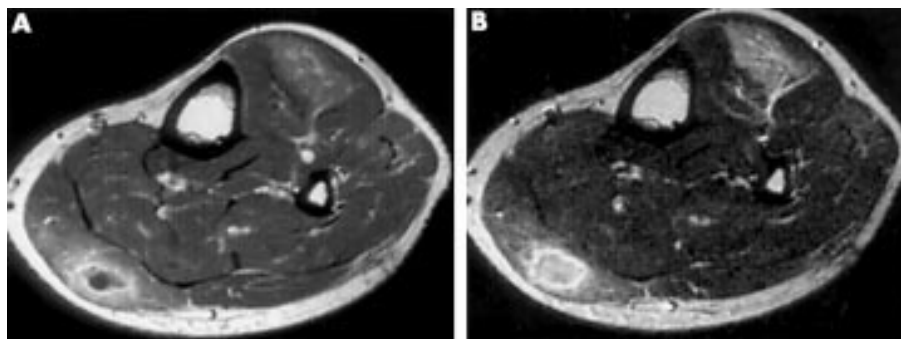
MRI of the lower legs was performed on the patient's first admission. An axial T₁ weighted image showed a focal mass-like lesion, about 3 cm in diameter, in a left gastrocnemius muscle with decreased intensity relative to that of normal muscle. After administration of gadolinium, the T₁ weighted image showed a well defined rim of contrast enhancement and a hypointense central area (A). An axial T₂ weighted image showed bright signal intensity in and around a focal mass-like lesion (B).
